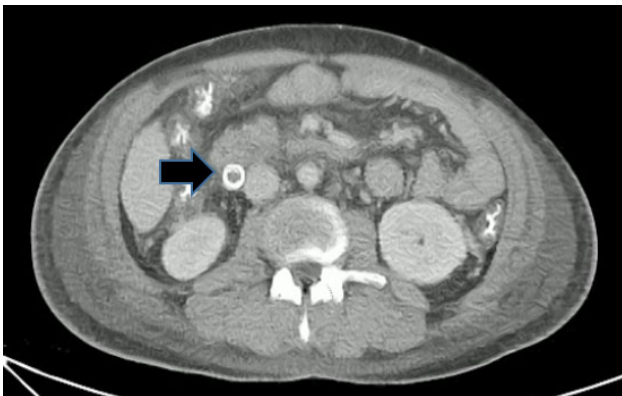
In the follow-up abdominopelvic CT, the vascular plug (arrow) was confirmed, and successful embolization of the previously dilated duodenal varix was observed.
